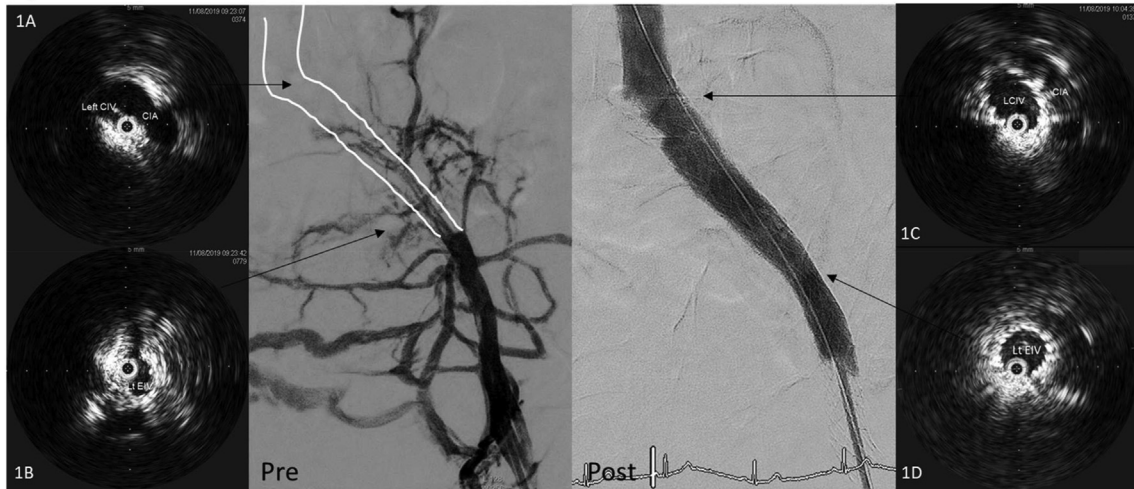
Venography of pre- and post-venous stenting of left CIV. IVUS image 1A shows compression of the left CIV by the CIA, 1B shows fibrotic changes at left EIV, 1C shows good expansion of left CIV stent against the CIA, and 1D shows good expansion of left EIV stent. CIV: common iliac vein, CIA: common iliac artery, EIV: external iliac vein, IVUS: intravenous ultrasound.
